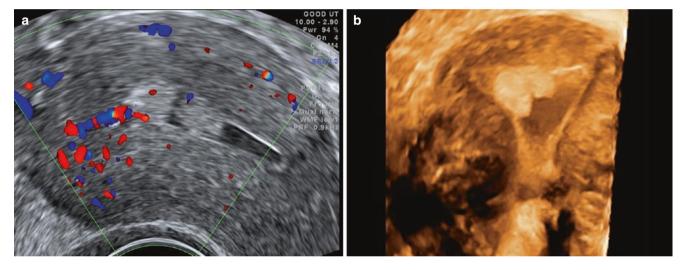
Confirming the presence of lesion with multiple modalities. Polyps seen on greyscale confirmed by (a) Doppler by the presence of a feeder vessel (the feeder vessel of one of the two polyps is seen in this image) and (b) by 3D rendering
